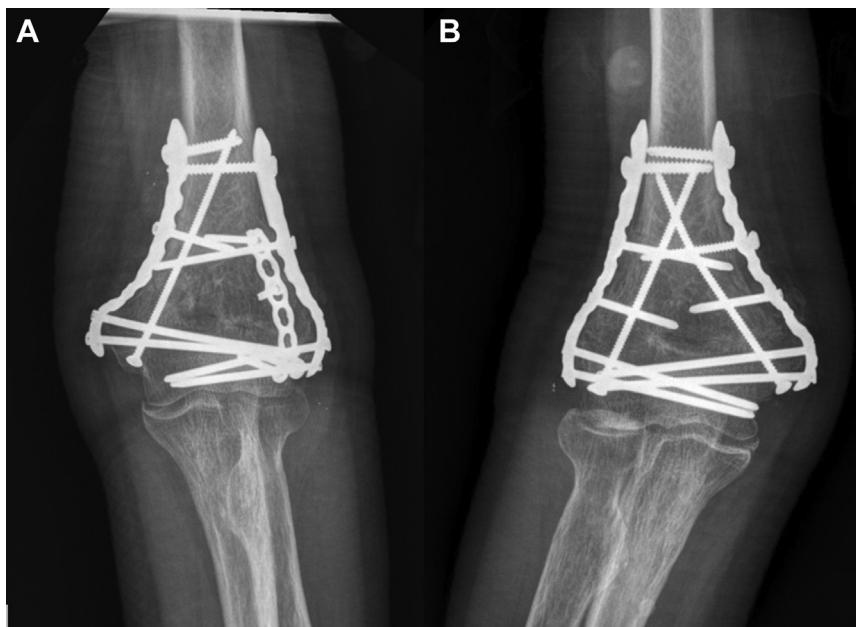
AP radiographs of the elbow demonstrating addition of (A) minifragment plates and a medial column screw and (B) medial and lateral column screws to augment fixation of the medial and lateral columns.
